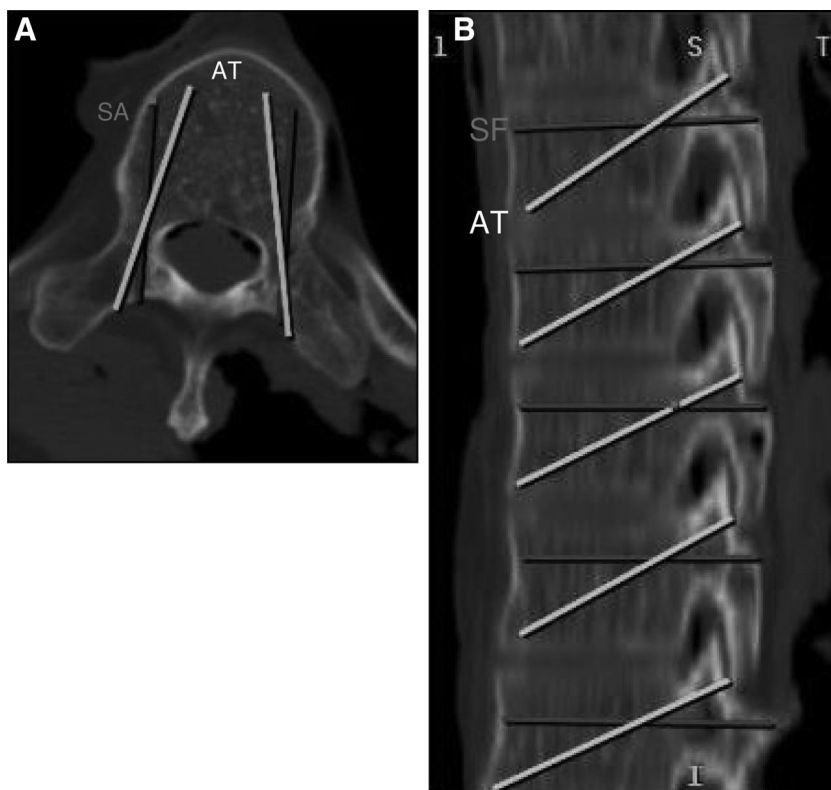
Thoracic pedicle screw trajectories on axial (A), and sagittal (B) CT slices. The anatomic trajectory is in white; the straight forward/straight ahead trajectory is in gray.
